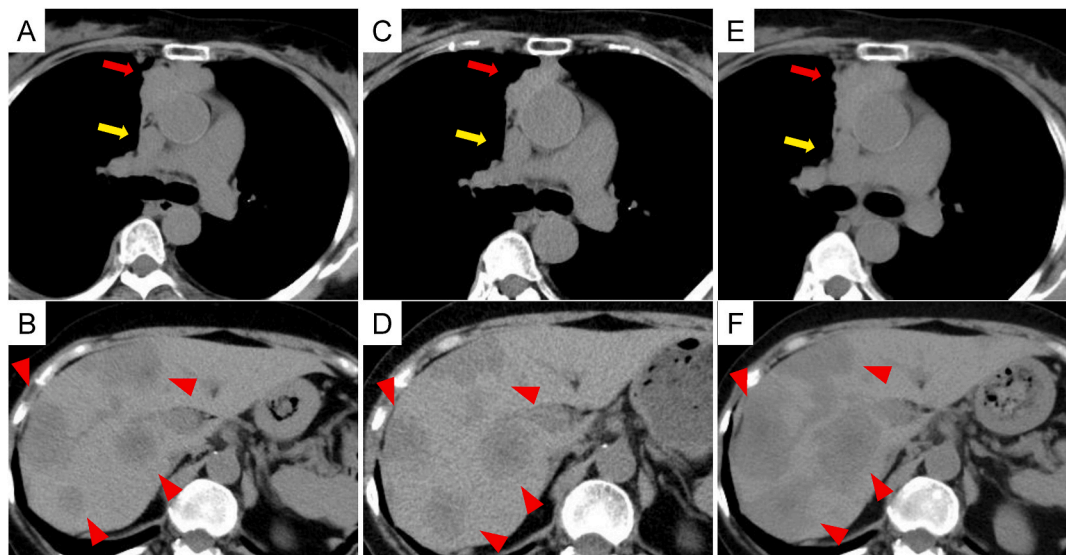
Chest and abdominal computed tomography (CT) performed in September of 2022 shows the primary tumor and mediastinal lymph-node metastasis (A) and multiple liver metastases (B). CT performed in December of 2022 shows shrinkage of the primary tumor (C), and mild enlargement of the liver metastases (D). CT performed in March of 2023 shows progression of the primary tumor (E) and liver metastases (F).
